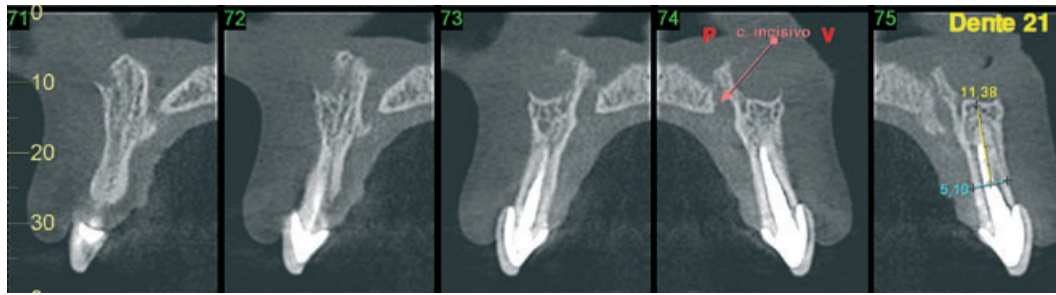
Computed tomography: transaxial slices at 5 years follow-up of the autogenous tooth transplantation. Red narrow: incisive canal.
